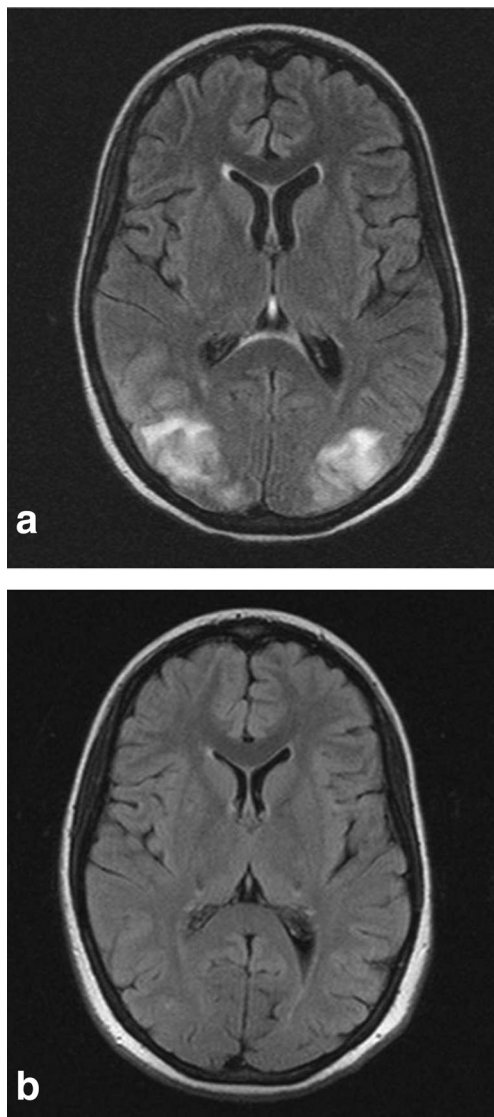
The MRI findings in patient 1 show a hyper-intense lesions in the parieto-occipital regions with b resolution on repeat MRI 2 months later
